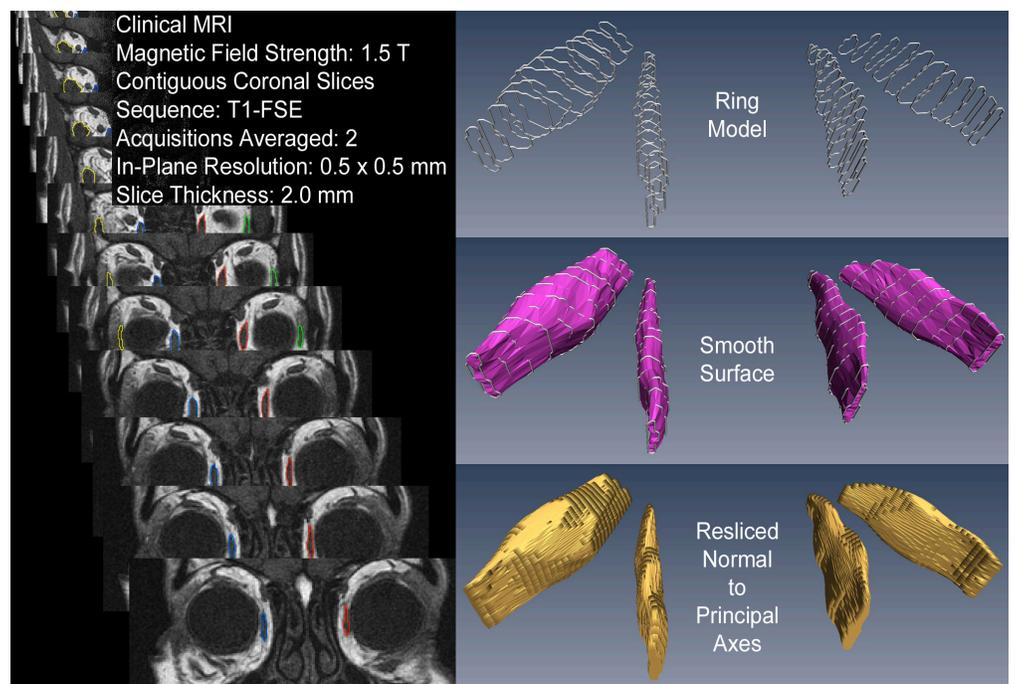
MRI Analysis. Coronal scans, collected as described in the text, were segmented manually with computer assistance, and the muscle contours used to build ring models of individual muscles. A smooth surface was then fitted using an automated, spline-based method, verified to approximate the ring model closely, which then was resliced normal to the principle axis of each muscle to yield accurate volume estimates, and true crosssections that can be meaningfully associated with longitudinal positions at better than 2 mm resolution.
